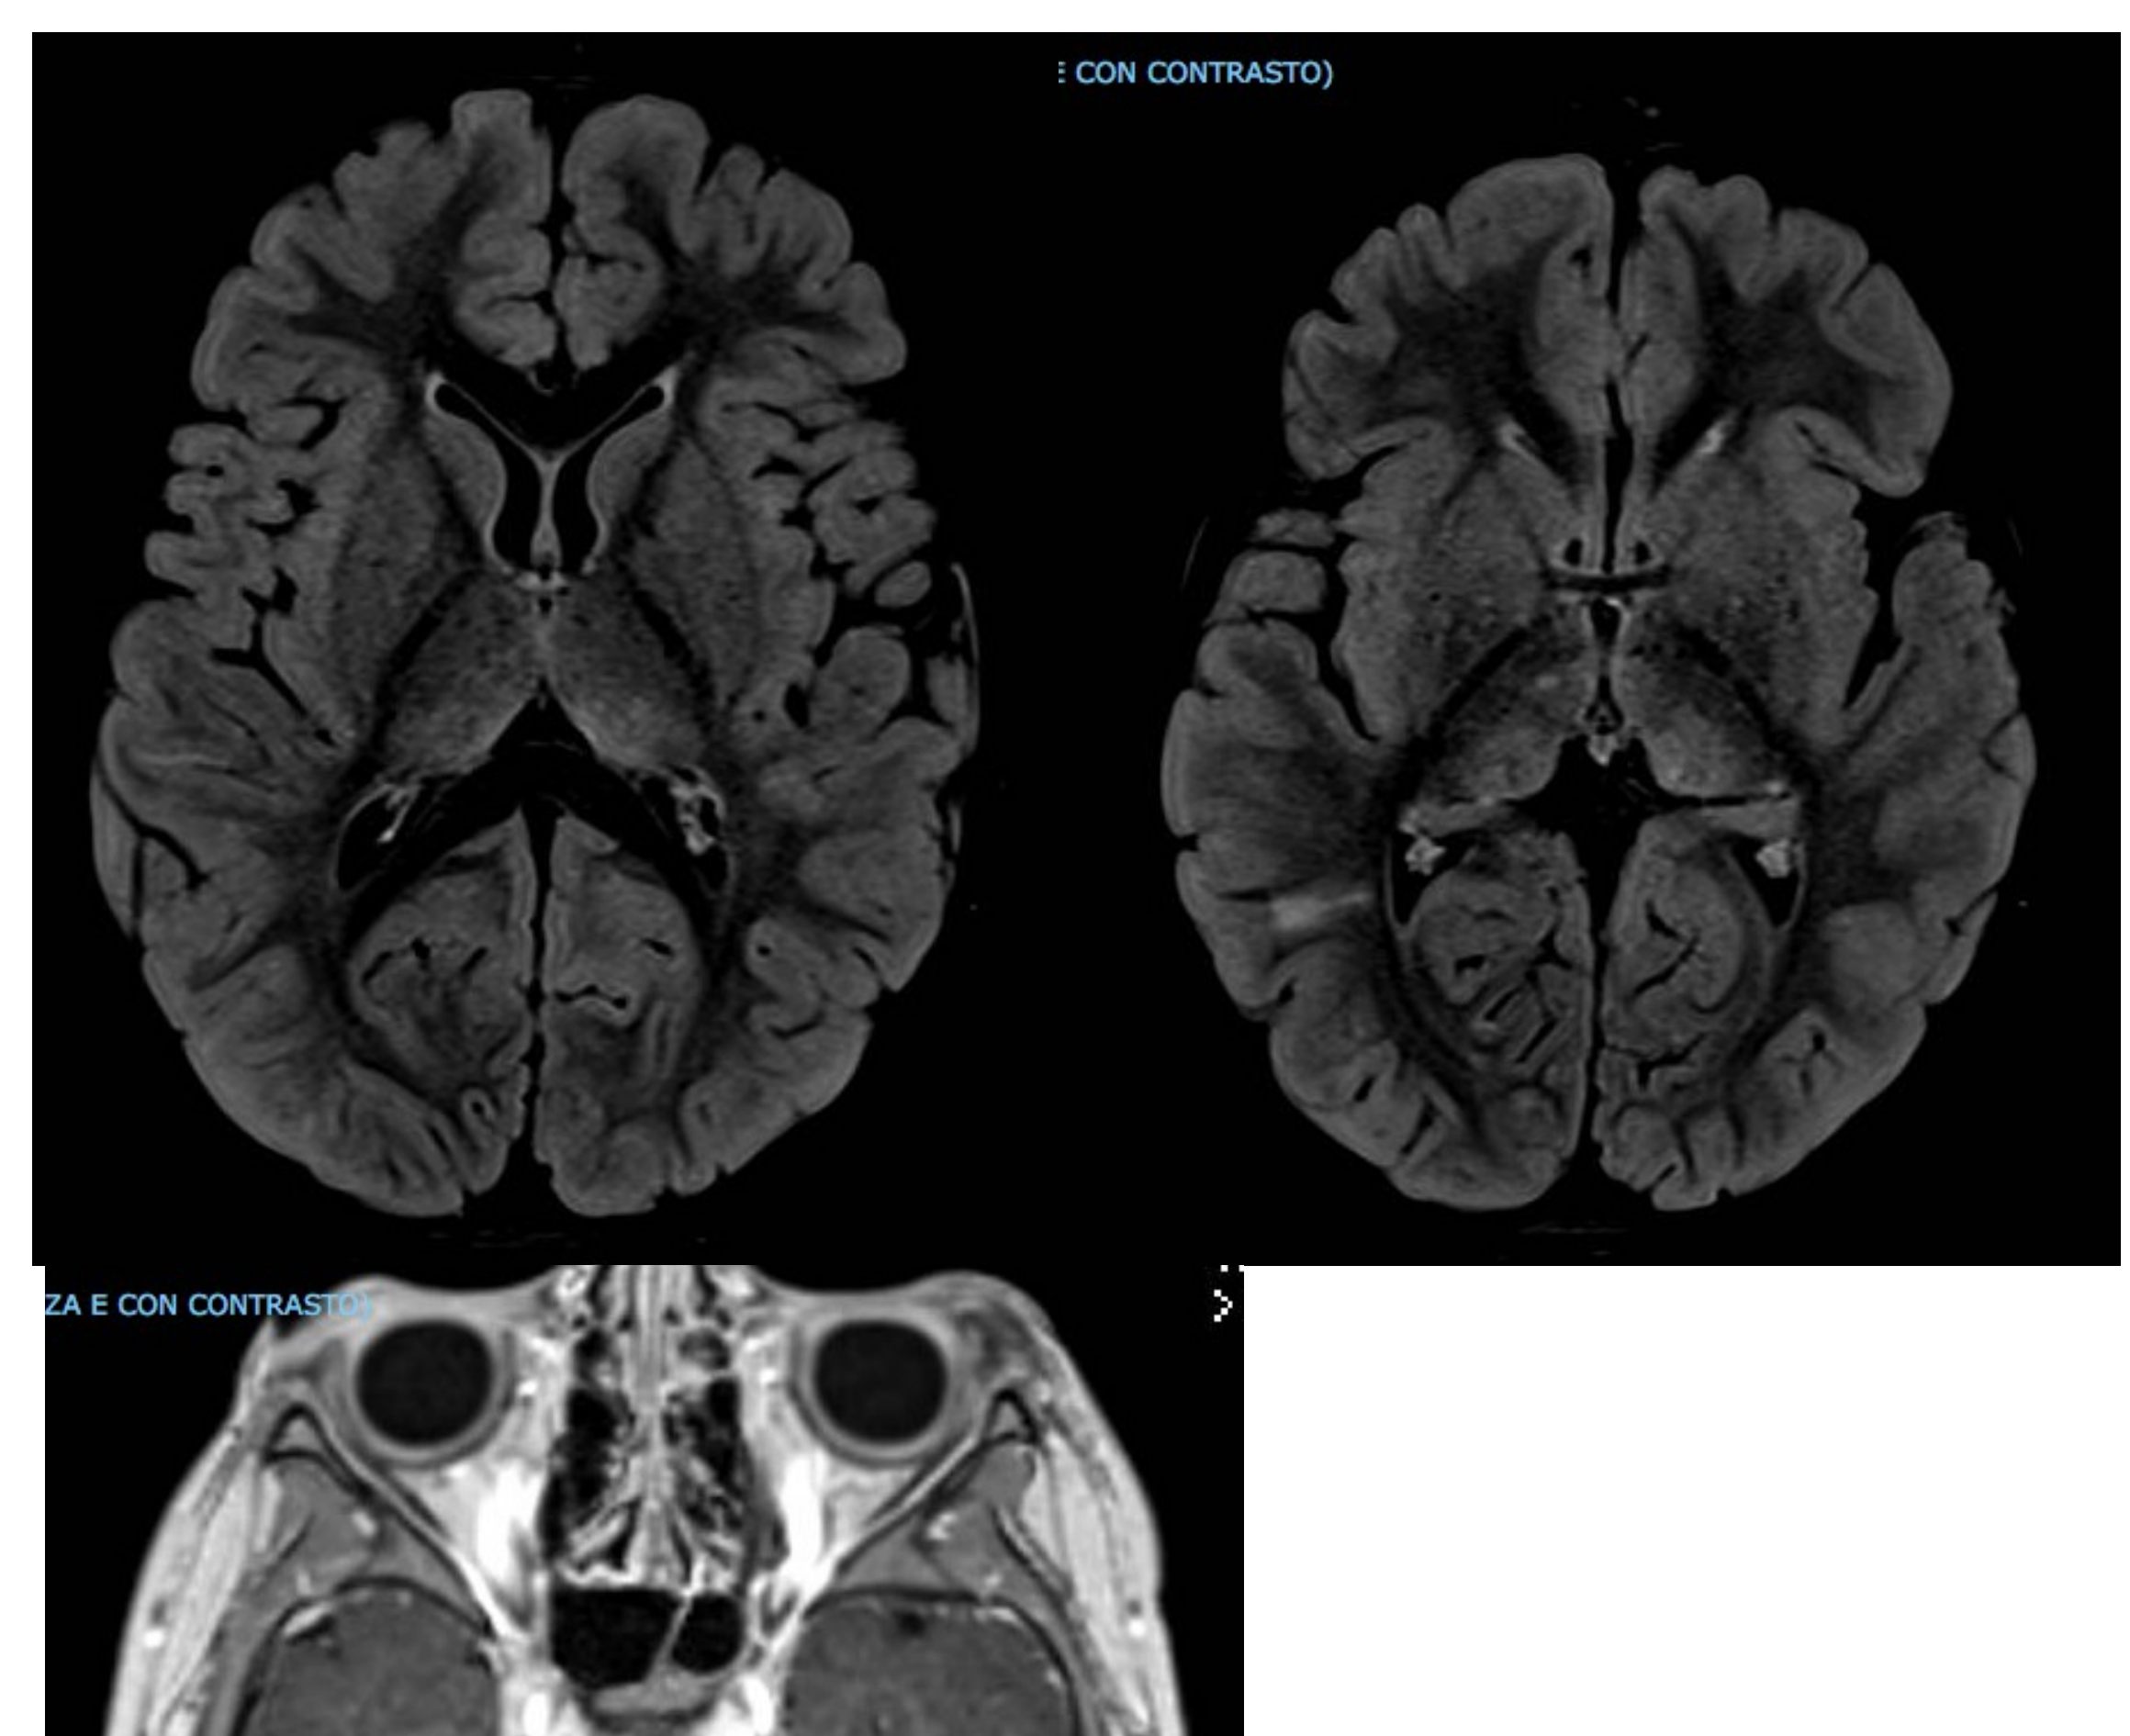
Brain MRI of the 3 years old boy showed optic nerves thickened and tortuous with post-Gd enhancement and T2-Hyperintensive lesions of thalami and right parietal subcortical white matter.
